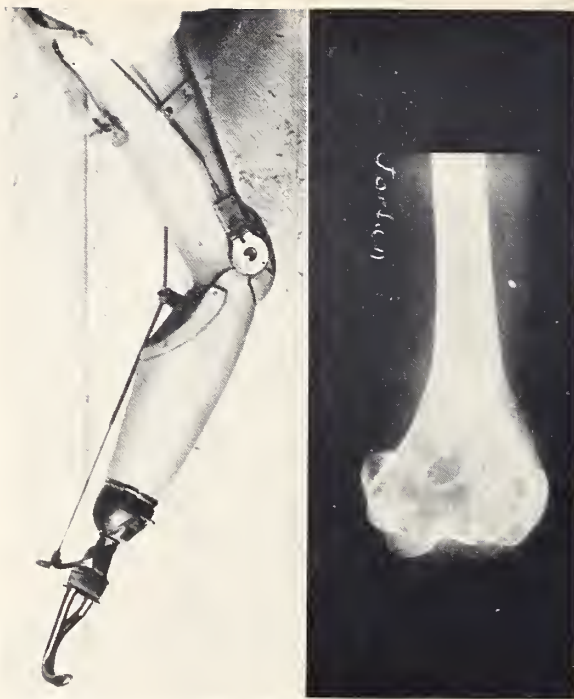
On the left is the elbow disarticulation prosthesis with outside locking elbow hinge; on the right, the x-ray of the elbow disarticulation. (By permission of J. of Bone & Joint Surg.)
